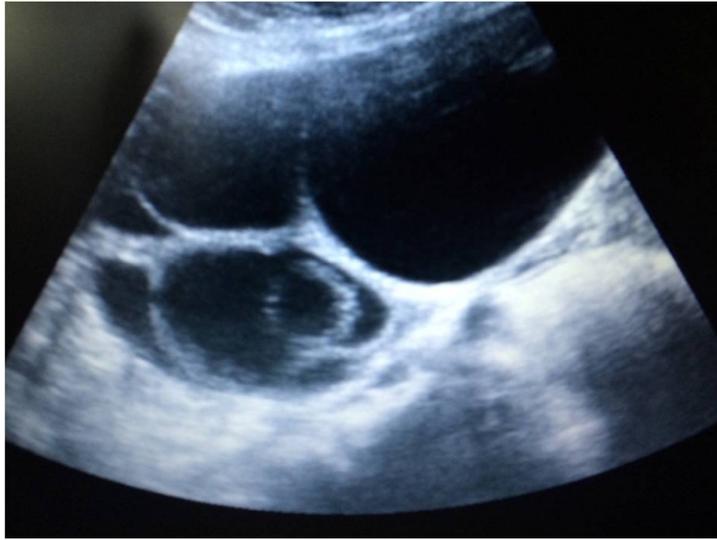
Spontaneous ovarian hyperstimulation syndrome: transvaginal sonographic image of enlarged ovarian cysts
